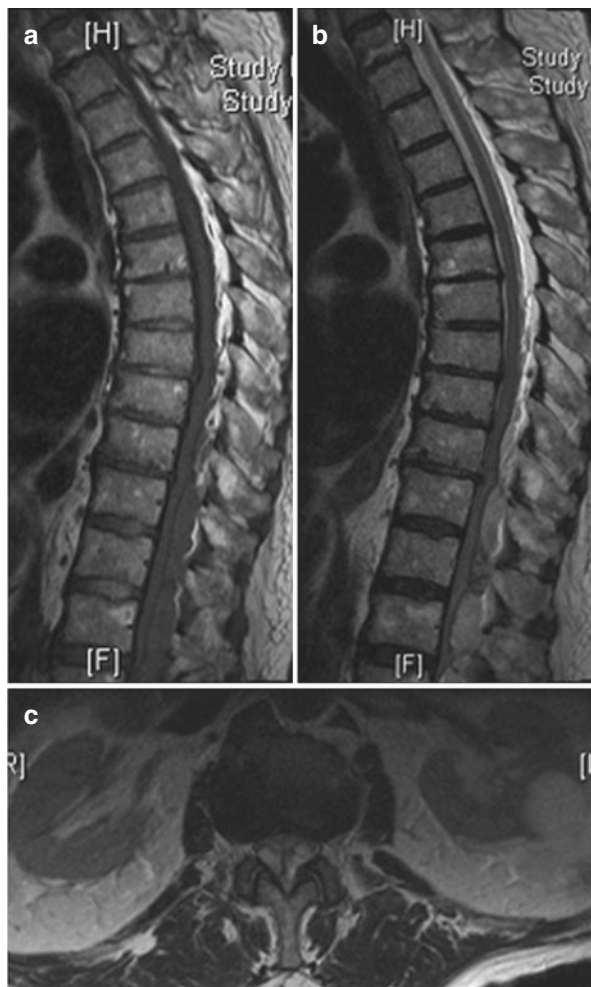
(a) Sagittal T1- and (b) T2-weighted MRI displays an epidural hematoma extending over multiple levels of the thoracic and lumbar spine with a convex appearance compressing the dorsal spinal cord in an 84-year-old patient with paraparesis Th1 (AIS A). (c) Absolute narrowing of the spinal canal due to the epidural hematoma. Axial T2-weighted image
